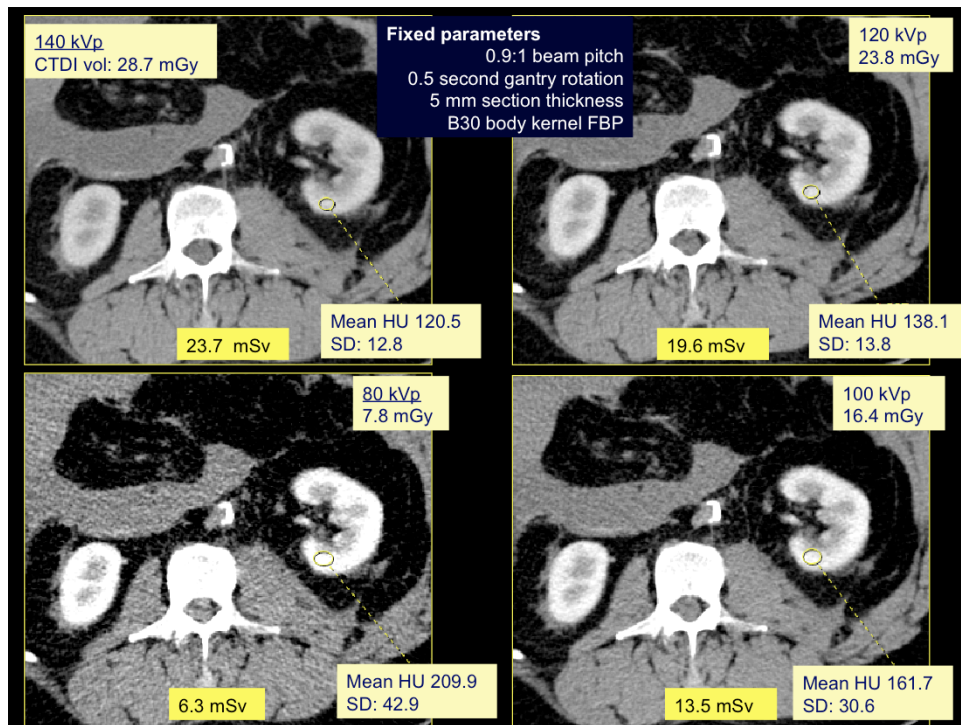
Post mortem CT at different kV settings in a patient with renal failure shows retained contrast and persistent nephrogram from pre-mortem CT. Lower kV results in increased image noise in soft tissue and paravertebral muscles, but also increases the CT numbers of contrast enhanced renal parenchyma. Objective measurements by placing region of interests in left renal cortex show increased image noise and increased HU values at lower kV images.
